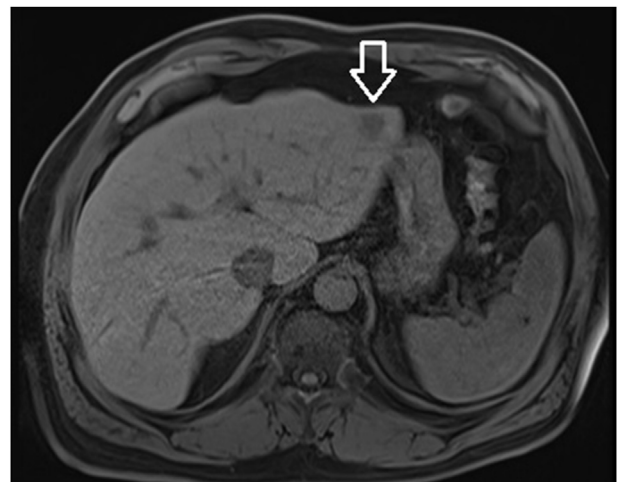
MRI Liver A poorly defined hypointense lesion is seen in peripheral segment two. It is close to the liver capsule.
